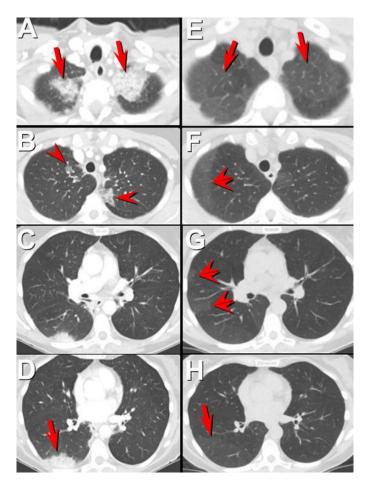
Comparison of presentation chest CT and follow up CT 86 days later. The presentation chest CT (A-D) shows multifocal areas of ground-glass opacity and consolidation (arrows A and D), with these parenchymal abnormalities resolving to pure ground-glass opacity on the follow up chest CT (Arrows, E and F). Note, however, that medial right and left upper lobe opacity at the presentation chest CT (arrowheads, B) resolves completely (F), but that new peripheral ground-glass opacity has developed on the follow up study (double arrowhead, F) in a previously unaffected region of lung. Similarly, new peripheral ground-glass opacity has developed in the right middle and lower lobe (double arrowheads, G) and the follow up CT.
